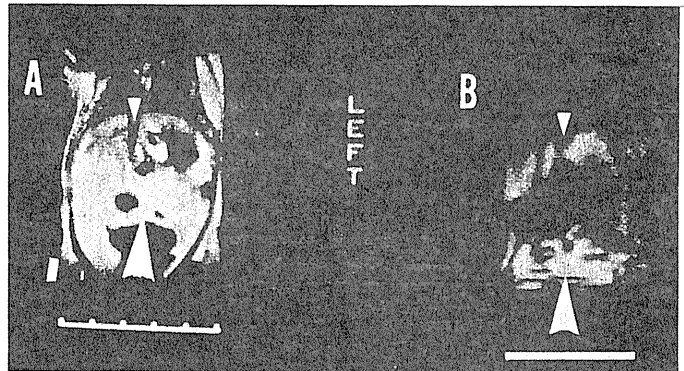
1.75% enflurane 吸入麻酔 60 分経過時の  $^{19}\text{F}$  MRI (腹部矢状方向すなわち側方から見た像, 図 3-B) およびこれに対応する腹部中央での  $^1\text{H}$  MRI (図 3-A). 図 3-B では肝臓 (小矢印) および腹腔内脂肪組織 (大矢印) より  $^{19}\text{F}$  MR の高信号が得られている. 肝臓の形態はこの撮影方向にて明瞭に描出されている. 図中の横線はおのおの 5 cm に対応している.
